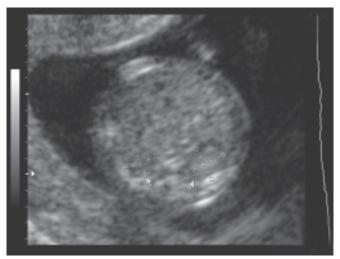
Transvaginal sonographic view of fetal kidneys at gestational week 11
